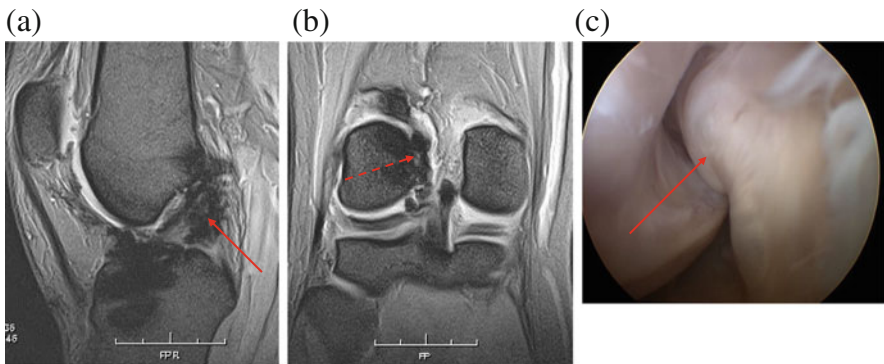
Appearances of the failed graft of Case 1. (a) Sagittal T2-weighted image showing the continuity of the graft (*solid arrow*). (b) Coronal T2-weighted image showing wavy and irregular appearance of the graft (*dotted arrow*). (c) Arthroscopic appearance of wavy and irregular appearance in its proximal 1/3
